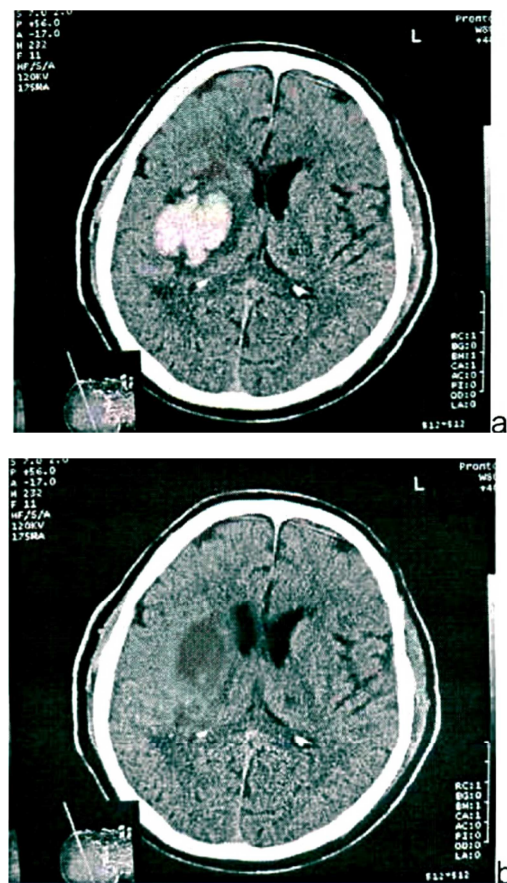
CT of brain with focal injury after trauma (a) and after 21 days of treatment (b). Pictures with higher resolution (and the clearer ones)
